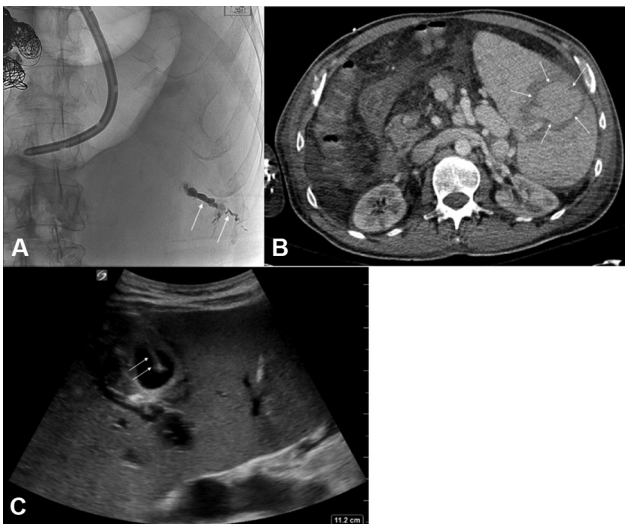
A 62-year-old man with cirrhosis, multifocal hepatocellular carcinoma treated by ablation, portal vein thrombosis with portal venous cavernous transformation, and Sarin classification type II gastroesophageal varices. He presented to the emergency department with large volume hematemesis and hemochezia. Emergent endoscopy revealed bleeding esophageal varices. Percutaneous transsplenic venous access (PTSVA) was performed with placement of an 8-French vascular sheath. Esophageal varices were embolized to complete stasis with a combination of coils, Gelfoam, and *n*-butyl cyanoacrylate. (A) Post-PTSVA tract embolization spot fluoroscopic image demonstrates the PTSVA tract embolized with microfibrillar collagen-contrast slurry (arrows). (B) Computed tomography performed on postprocedure day 2 for staging of liver disease demonstrates a 5.6 cm splenic vein pseudoaneurysm (arrows). (C) Gray scale ultrasound image demonstrates 21-G Chiba needle access into the splenic vein pseudoaneurysm (arrows).
